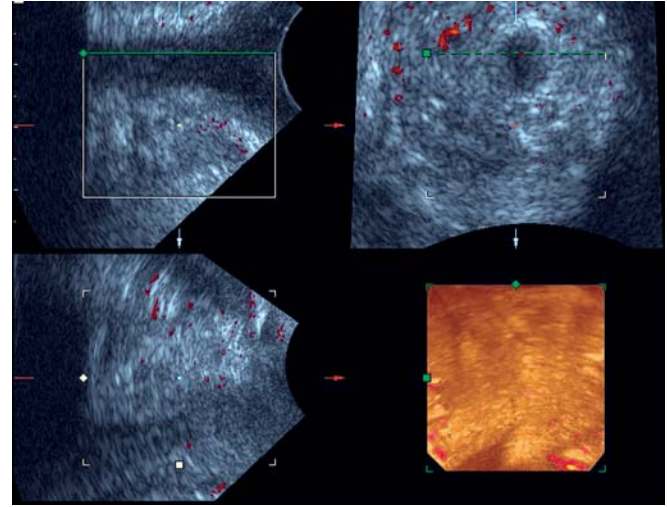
3D tomographic ultrasound imaging with 2D and power Doppler information in a patient on perineal exercises and local estrogen cream application. Note the increased vascular signals in the top right frame when compared with figure 55
